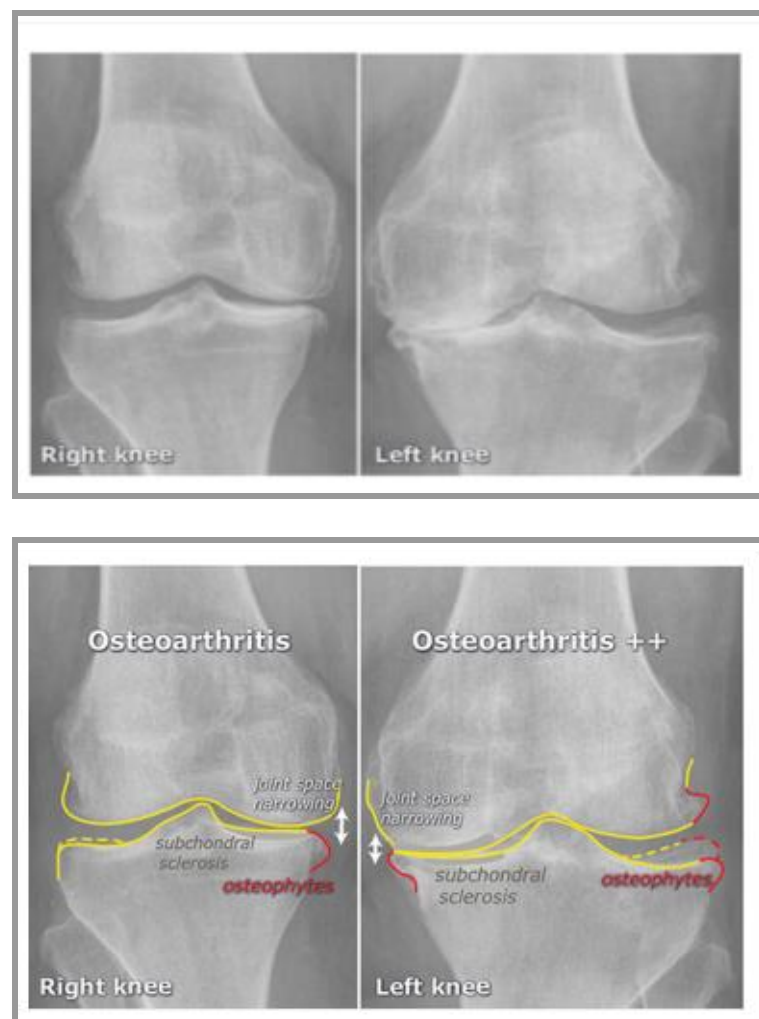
Radiographic features of osteoarthritis knee⁵¹.
